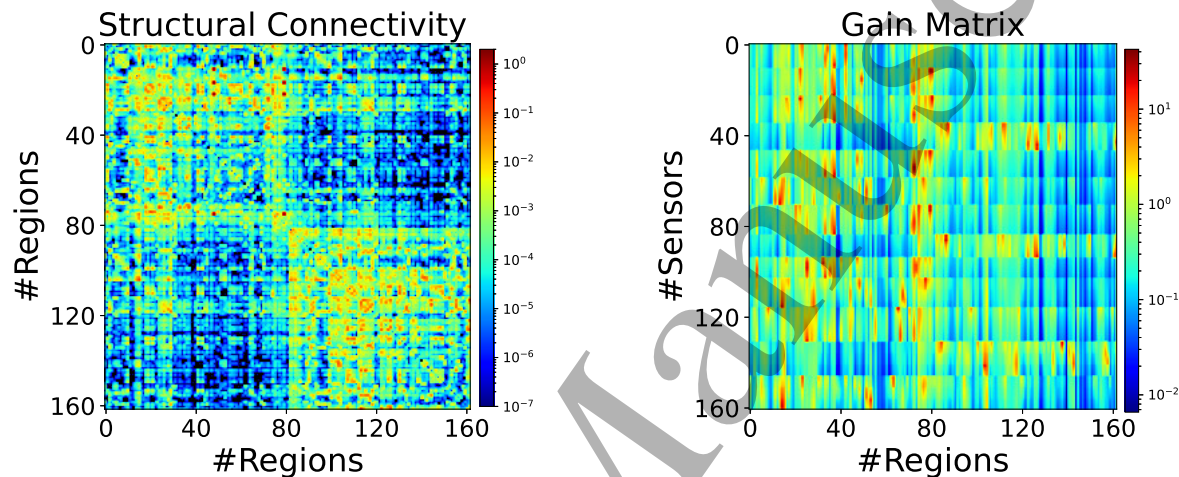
(A) Structural connectivity matrix of a patient, whose entries represent the connection strength between the brain regions, is derived from diffusion MRI tractography. Using VEP atlas, the brain of the patient is parcellated into 162 different regions and (B) Gain matrix of a patient. Each element represents the inverse-squared distance between the region and the sensor.
